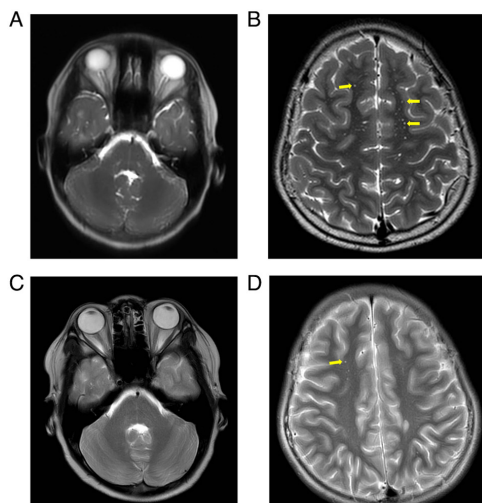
MRI features before and after treatment. The orbit MRI is shown in the left panel, while the cranial MRI is shown in the right panel. (A and B) Pre-treatment MRI. (A) Significant thickening of the optic nerve with enhanced visibility. (B) Multiple punctate T2-weighted imaging high-signal lesions (the yellow arrows indicate some of the lesions) in the intracranial white matter. (C and D) Post-treatment MRI; (C) the optic nerve appears slightly thinner compared to before and (D) there is a reduction in the extent of intracranial lesions (the yellow arrow indicates one of the remaining lesions). MRI, magnetic resonance imaging.
